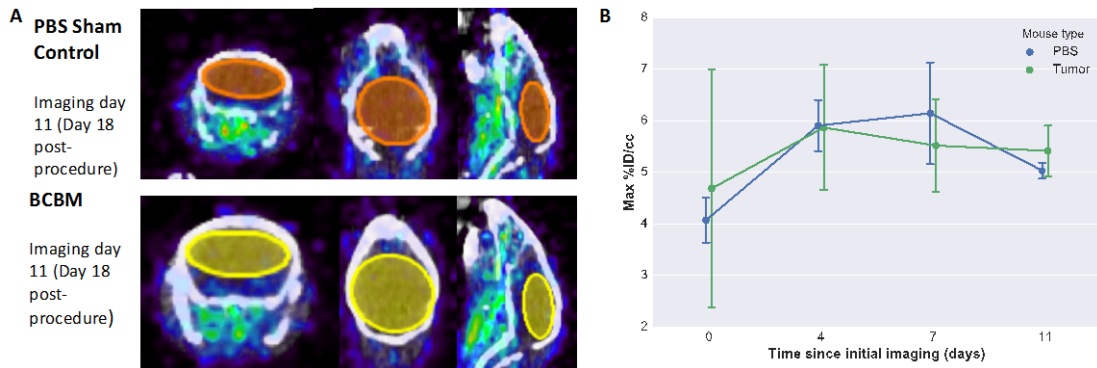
^{18}F FaraG uptake over the natural course of BCBM growth. A. axial, coronal, and sagittal fused PET/CT images demonstrating volumes of interest from which statistics were derived using AMIDE. B. Maximum injected dose per volume measured from VOIs of PET/CT images
